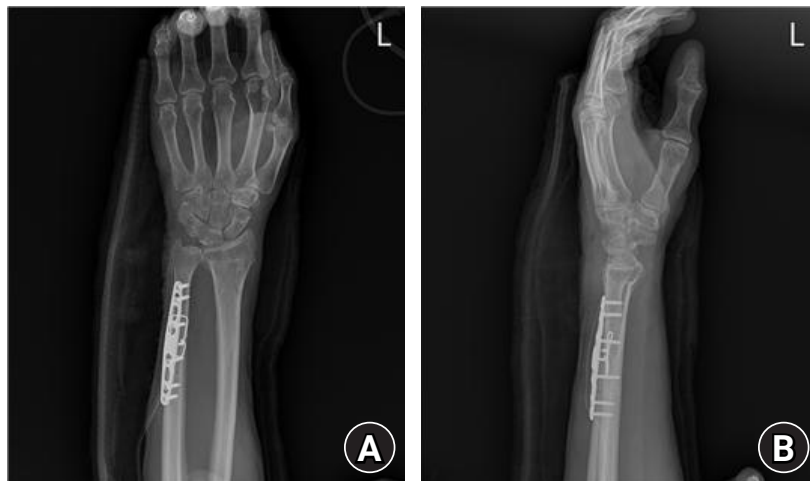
A 63-year-old male patient. Immediate postoperative (A) anteroposterior and (B) lateral radiographs after transosseous wiring-assisted plate fixation.
